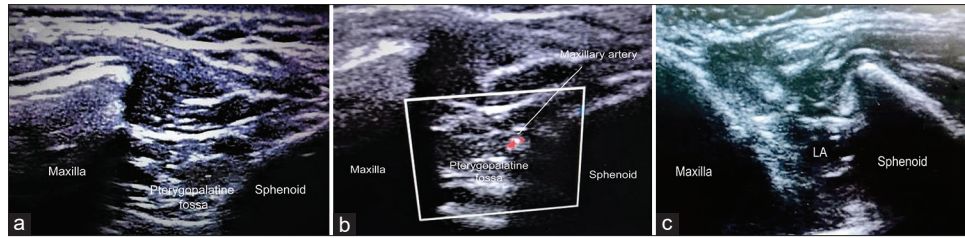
Ultrasound-guided suprazygomatic maxillary nerve block. (a) Sono-anatomical view of the suprazygomatic maxillary nerve block. (b) Doppler flow (red) identification of the maxillary artery. (c) Spread of local anesthetic in the pterygopalatine fossa. LA: local anesthetic
